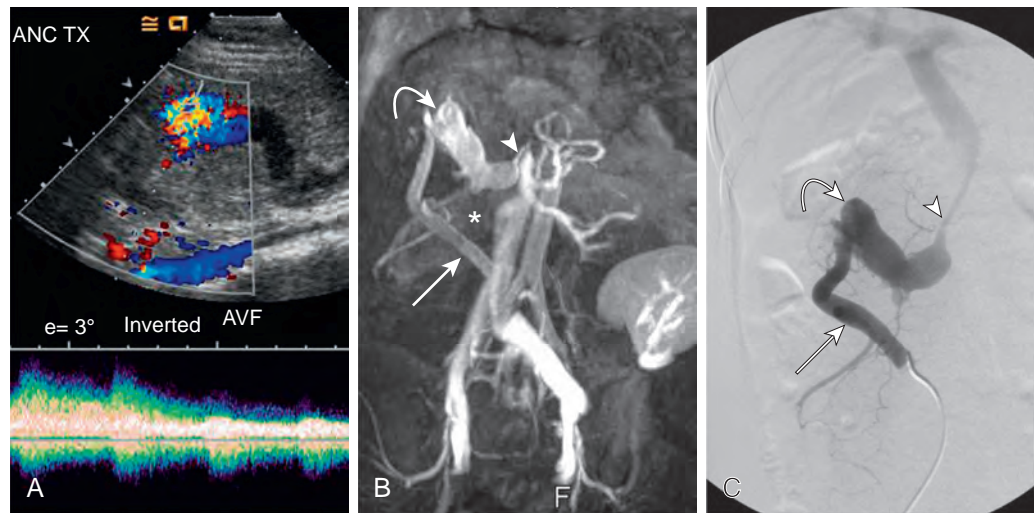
Iatrogenic arteriovenous fistula between donor superior mesenteric artery and donor portal vein in a 29-year-old woman 2 weeks after SPK transplantation. A. Duplex Doppler US image of a large vessel in the head of the pancreas shows a high-velocity, low-resistance waveform typical of an arteriovenous fistula (AVF). B. MRA demonstrates a dilated graft artery (arrow) and superior mesenteric vein (curved arrow). Focal narrowing of the distal vein graft (arrowhead) proximal to the anastomosis is also seen (asterisk, pancreas transplant). C. Selective arteriography confirms the fistula and better demonstrates an associated venous outflow stenosis (arrowhead). The fistula was embolized, but explantation of the allograft was subsequently performed for sepsis (arrow, dilated graft artery; curved arrow, dilated graft vein). (From Vandermeer F, Manning MA, Frazier A, et al: *Imaging of whole-organ pancreas transplants*. *RadioGraphics* 32:411–435, 2012.)
